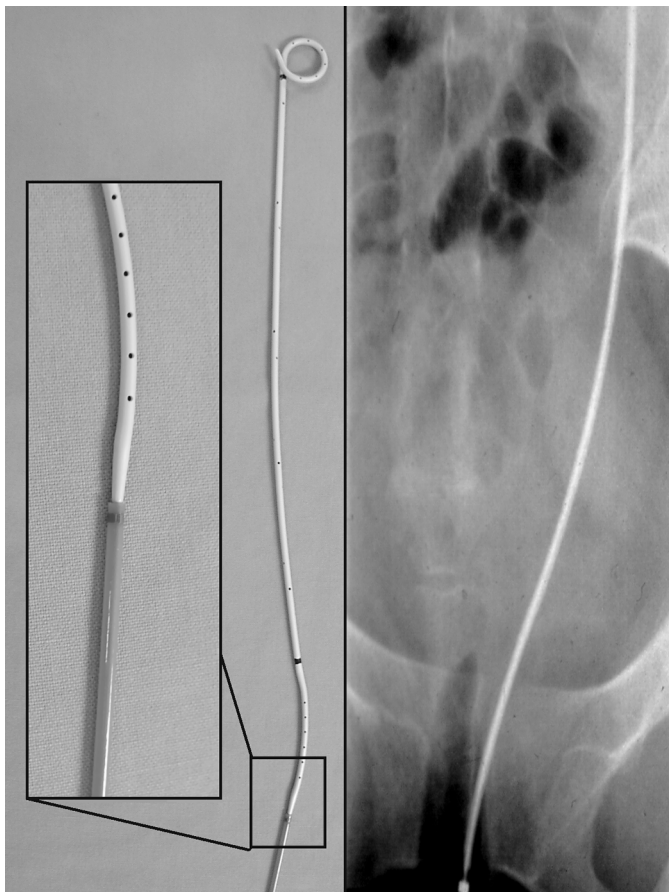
Radiographically, the metal-tipped pusher is at the correct level of the symphysis for a female patient and the 10-Fr sheath has been withdrawn. The metal-tipped pusher is positioned at the lower border of the pubic symphysis in women and at the level of the mid pubic symphysis in men. Once the metal-tipped pusher is in the correct position, the 10-Fr sheath is backed-up over the guidewire.
